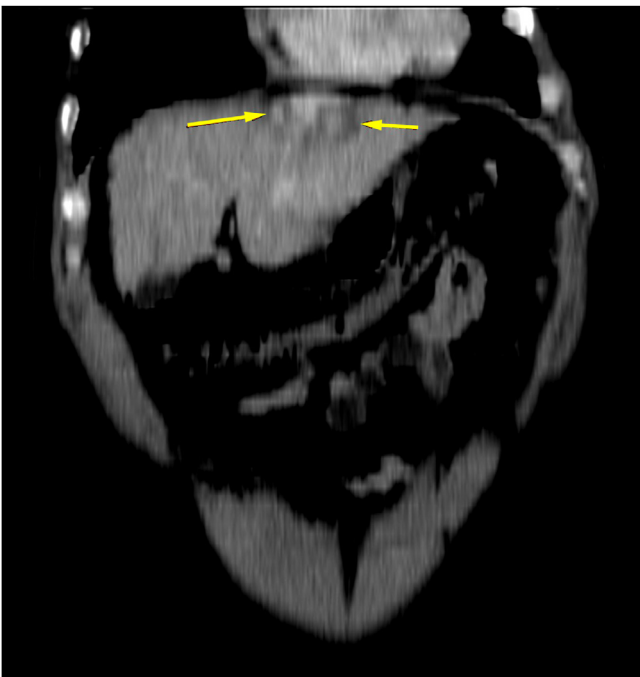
Coronal views of a contrast enhanced CT scan of the liver revealing a large tumour in the second and third segment of the liver.
